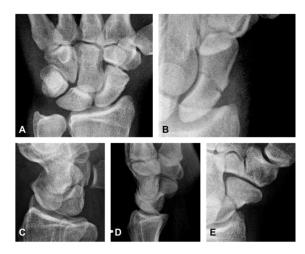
Five radiographic views of the scaphoid
